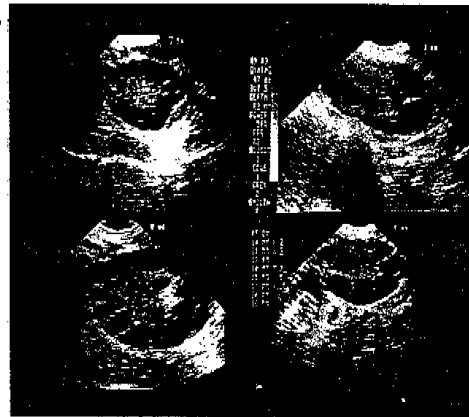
Four sonographic visualizations of the "Necklace sign," which is correlated with the risk of OHSS.
